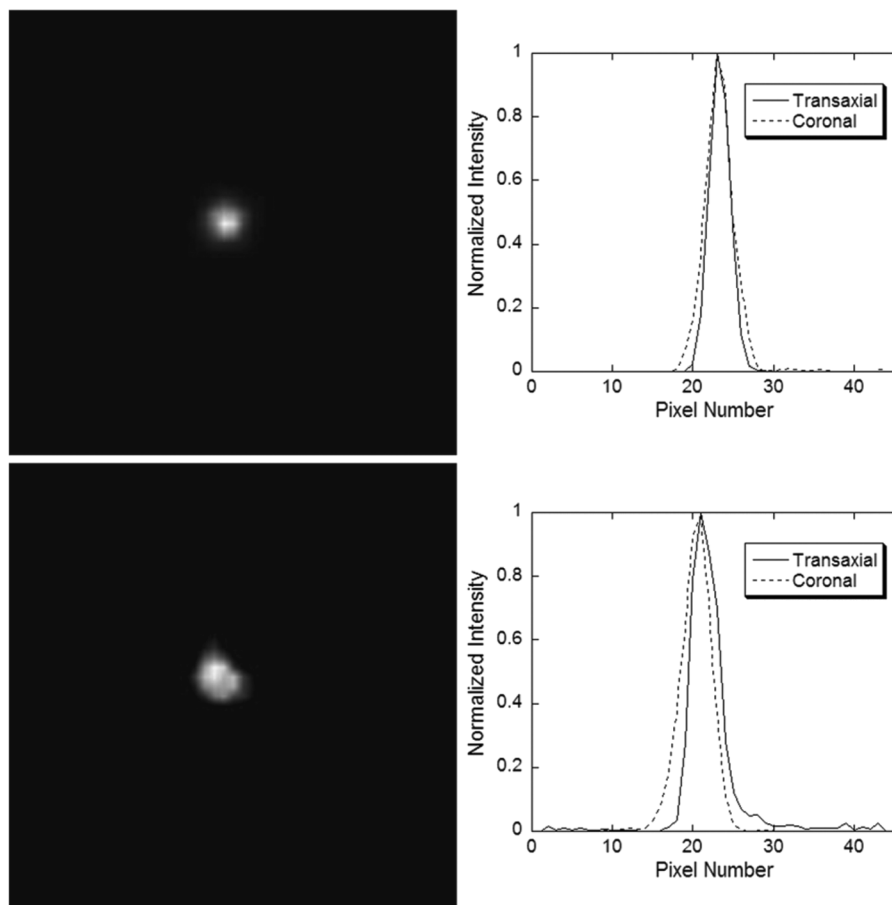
Reconstructed coronal SPECT slice from a 140 keV (top row) and 511 keV (bottom row) point source and its corresponding point spread functions in both the transaxial and coronal planes.
